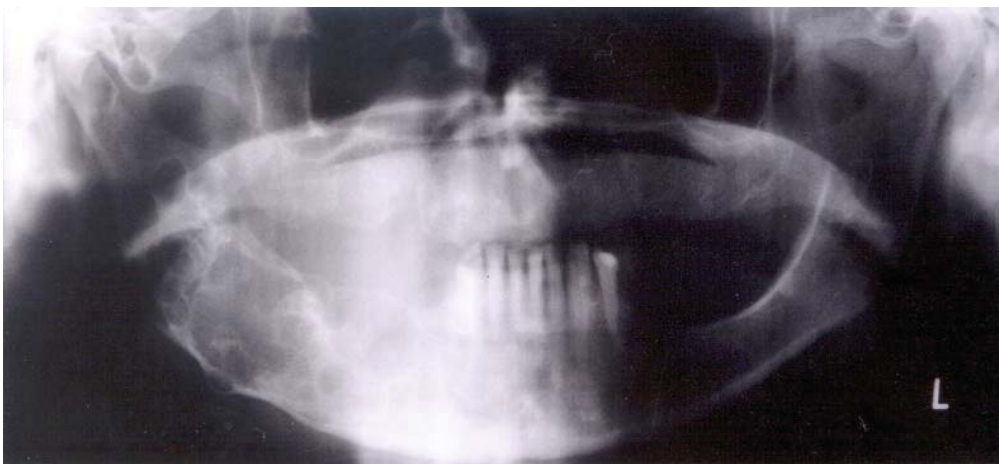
Orthopantomograph with odontogenic keratocyst
